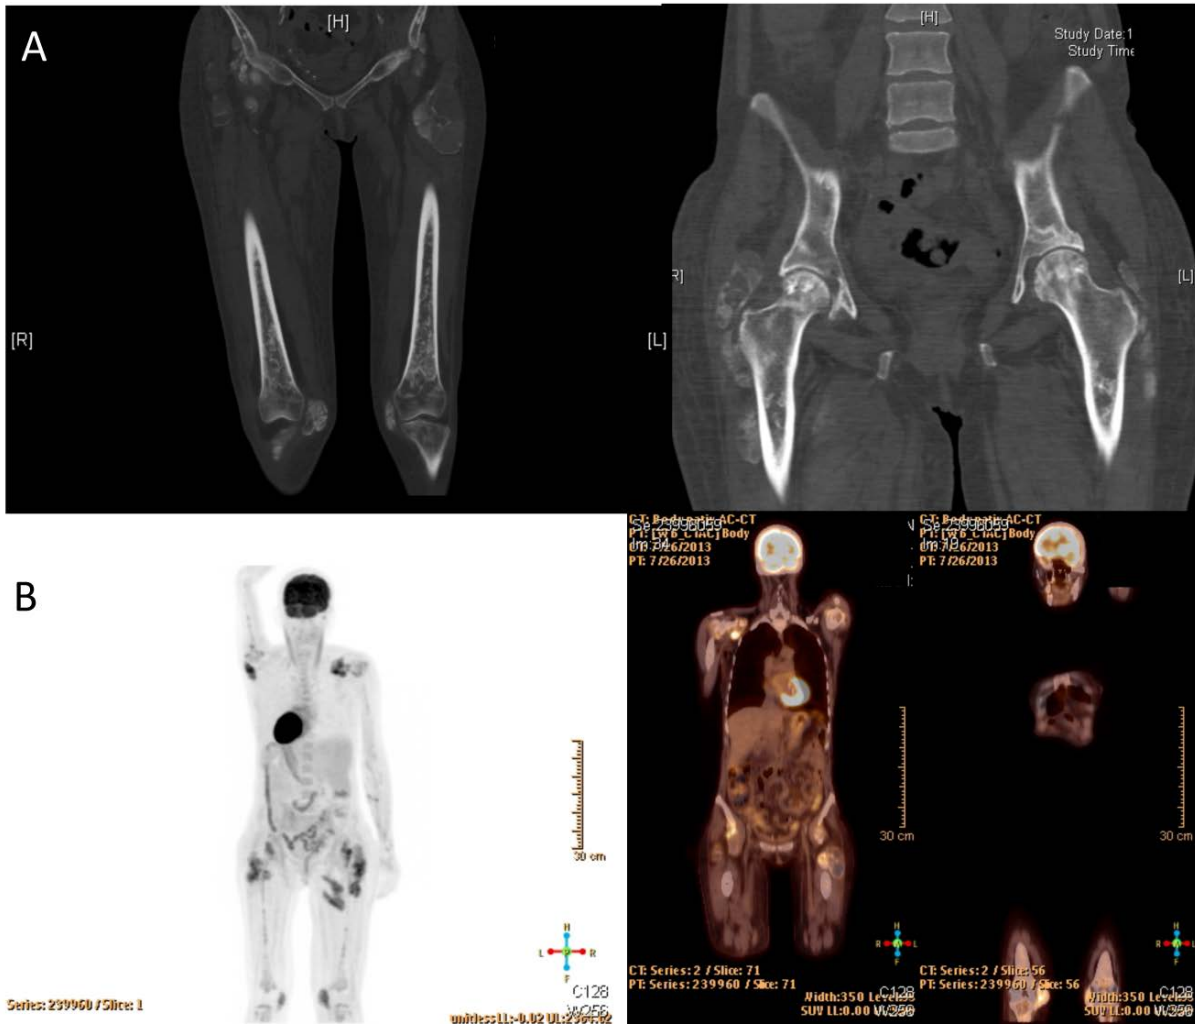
A. Sclerosis of both distal and proximal femurs is evident. Note is also made of the tumorous soft-tissue calcification adjacent to both trochanters and at other sites. Figure 2B. Total-body PET-CT shows markedly increased glucose metabolism at numerous skeletal sites, particularly proximal and distal long bones and pelvis.
